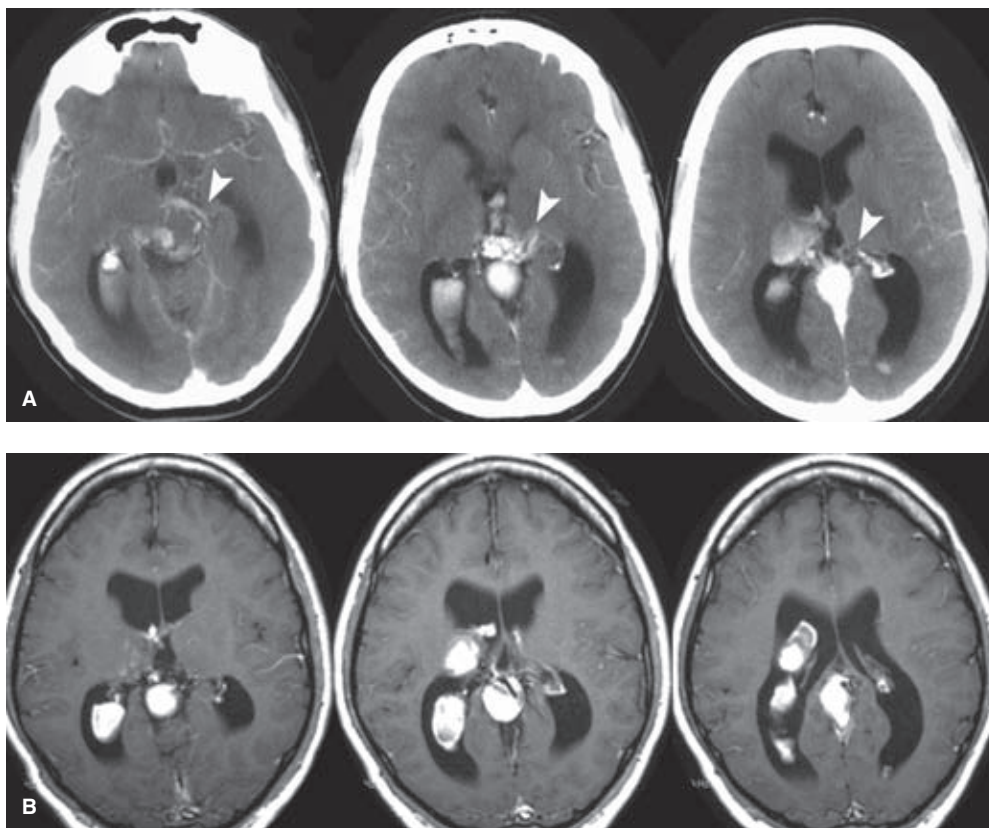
(A–E) Choroidal-type vein of Galen aneurysm in a 28-year-old adult. A 28-year-old male who had been seen in childhood at a major pediatric center and told that he had a malformation in his brain best left untreated at that time presented in adulthood with his first complication, a mild intraventricular hemorrhage. His contrast-enhanced CT scan (A) shows moderate ventriculomegaly with intraventricular hemorrhage and a profusion of enhancing vessels in the perimesencephalic and quadrigeminal cisterns (*arrowheads*). The distended “galenic” sac is evident on the CT scan. The contrast-enhanced T1-weighted MRI (B) and T2-weighted MRI (C) demonstrate the same findings with a complexity of vascular findings suggesting that this is a choroidal type of lesion. (*continued*)
